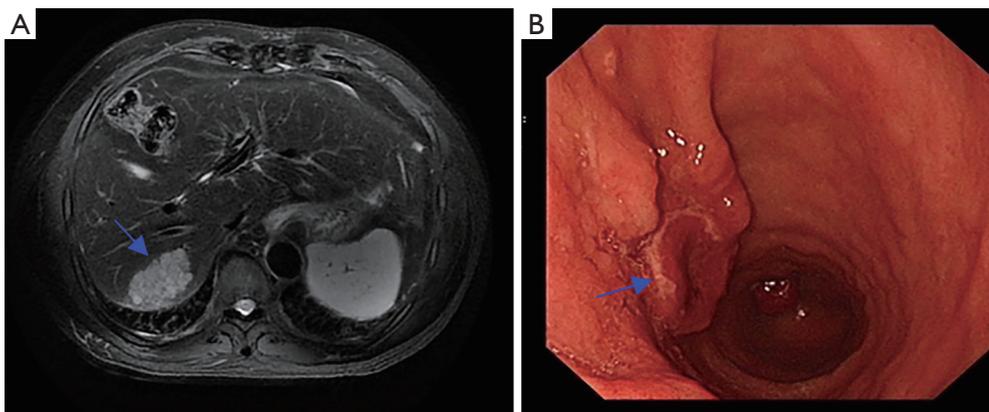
Clinical auxiliary examinations. (A) Liver MRI showed an isolated heterogeneous enhanced tumor in liver segment VII (arrow); (B) upper endoscopy showed a Borrmann type 1 tumor in the antrum of the stomach (arrow). MRI, magnetic resonance imaging.
